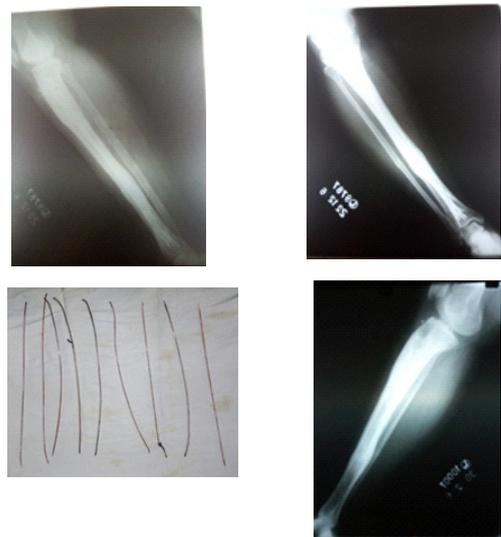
Pre-operative Radiograph(multiple ender's nails) Fig-3:- Nine Ender's Nail including one broken. Fig-4:- Post-operative Xray
